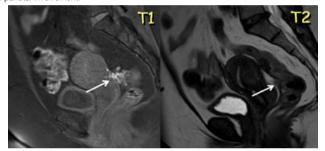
Nodules in the pouch of Douglas involving the anterior aspect of the rectum on magnetic resonance imaging.
